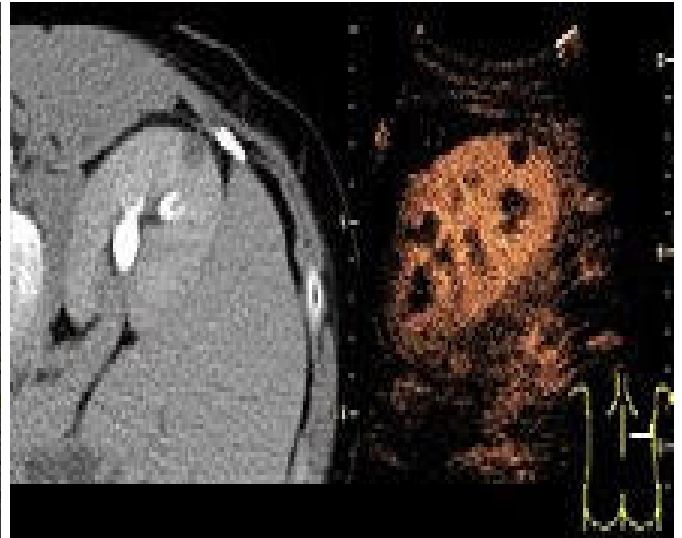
Unspecific cortical lesion on CT is confirmed cystic and benign with contrast-enhanced renal ultrasonography using image fusion.
